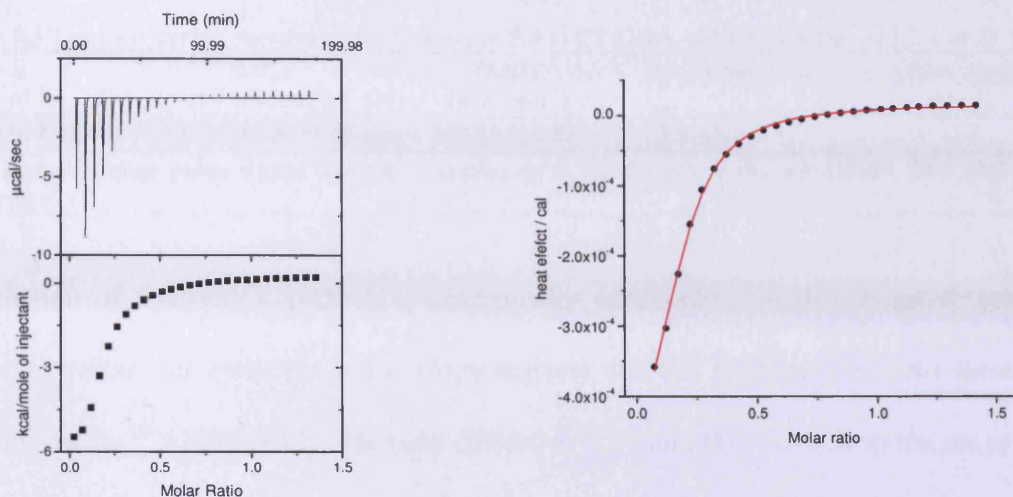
Titration of a 6.85 mM solution of 5.4 into a 1.0 mM solution of CT DNA in 25 mM MOPS, 50 mM NaCl and 1 mM EDTA, pH 7, at 25 °C (left). Integrated heat effects for the same titration analysed in terms of one binding site size model with aggregation not included.
